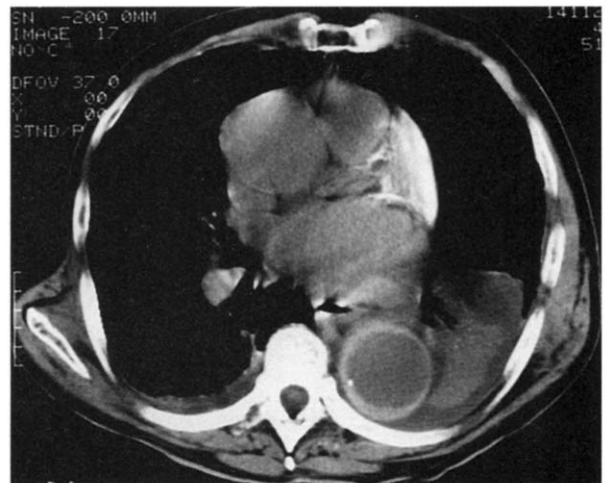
Computed tomographic scan of a patient with an intramural hematoma.
